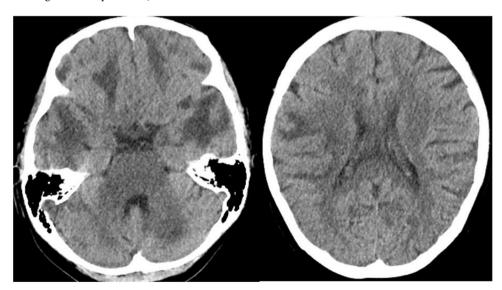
Computed tomography (CT) of the head showing worsening lucency with mass effect in the bilateral cerebral hemispheres.
